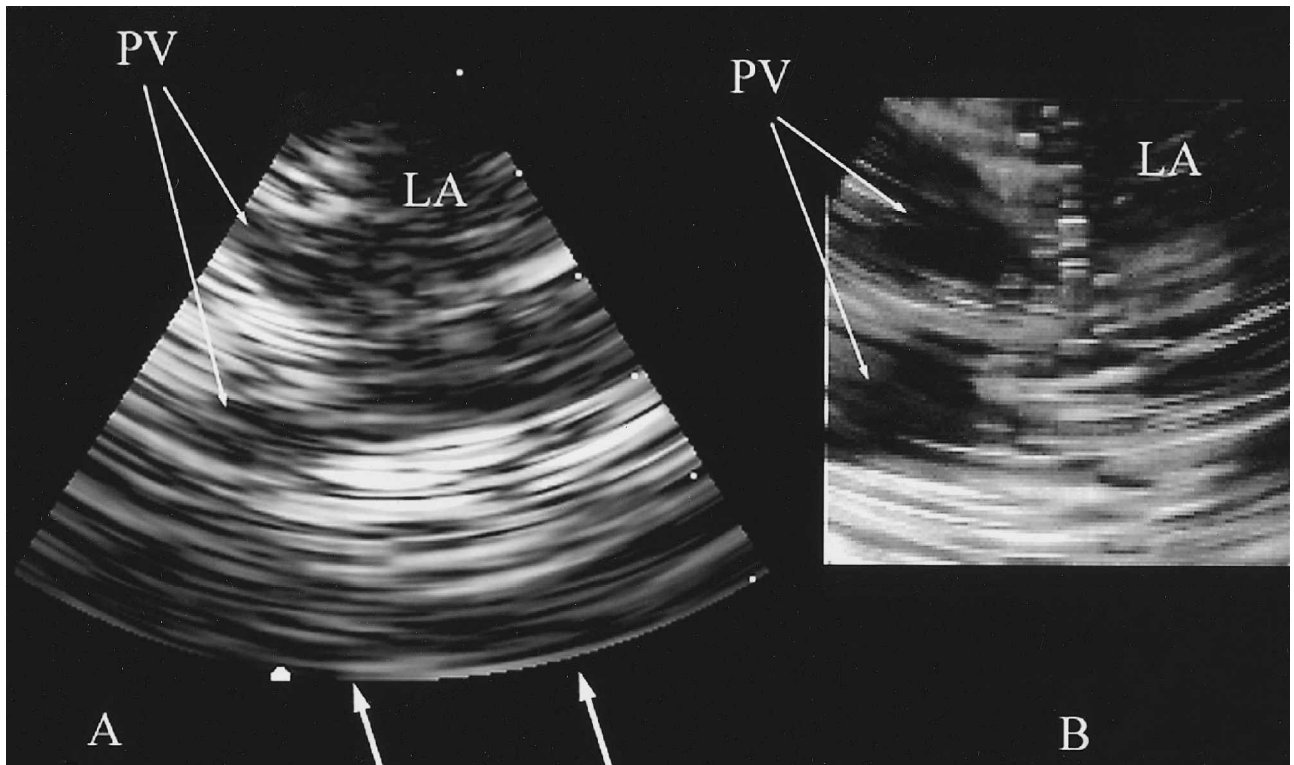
Three-dimensional intracardiac echocardiographic scan with an imaging catheter in the coronary sinus (CS) including (A) a sector image of the left pulmonary veins (PVs), (B) simultaneous real-time three-dimensionally rendered image of an en face view of the PVs.
